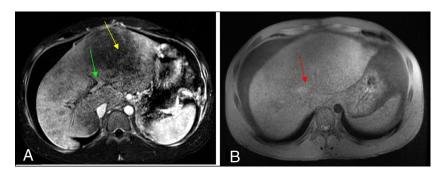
Abdominal magnetic resonance imaging. (A) Nonvisualization of the branches of the left portal vein, indicating thrombosis (green arrow). The main portal vein looks enlarged, most likely acute thrombosis. Also seen is left lobar enlargement—likely from acute congestion (yellow arrow). (B) Hyperintense signal (red arrow) showing hepatic vein thrombosis, without visualization of distal flow.
